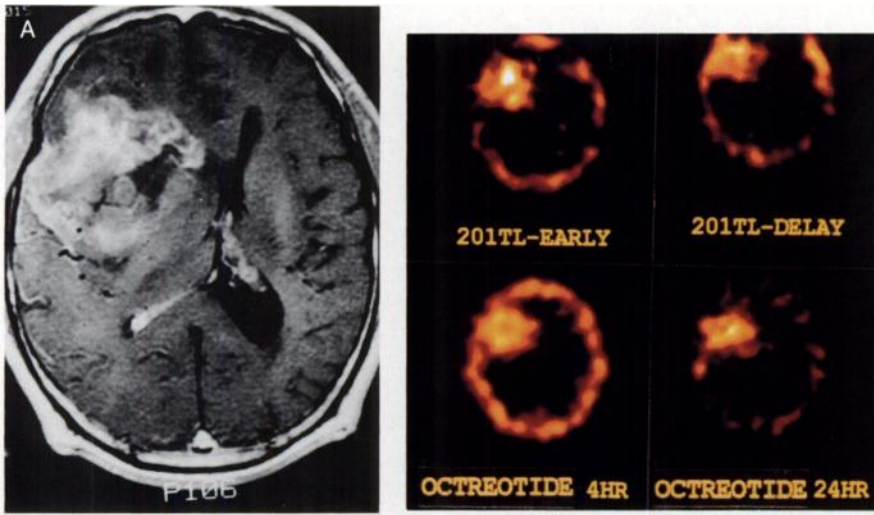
A 65-yr-old male with glioblastoma multiforme at the right frontotemporal area. (A) Gd-enhanced MRI shows a large tumor mass with irregular inhomogeneous contrast enhancement and compression of ipsilateral lateral ventricle. (B) Thallium and an ^{111}In -pentetreotide image reveal intense radiotracer uptake on both early and delayed studies.
